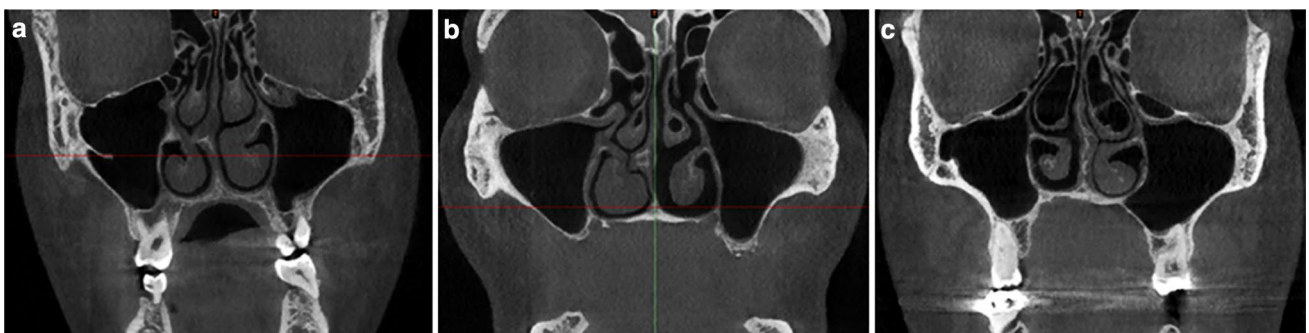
Coronal CBCT images showing the definitions of concha bullosa. a Lamellar concha bullosa. b Bullous concha bullosa. c Extensive concha bullosa
